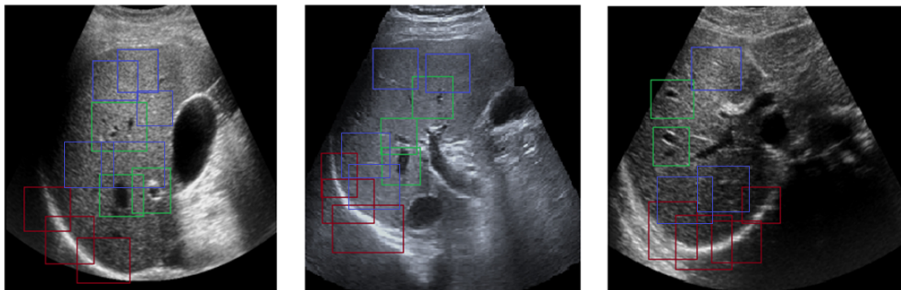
Ultrasonic liver images. Red boxes indicates the diaphragm, green boxes indicates periportal veins and blue boxes indicates RoI corresponding to homogeneous texture.
